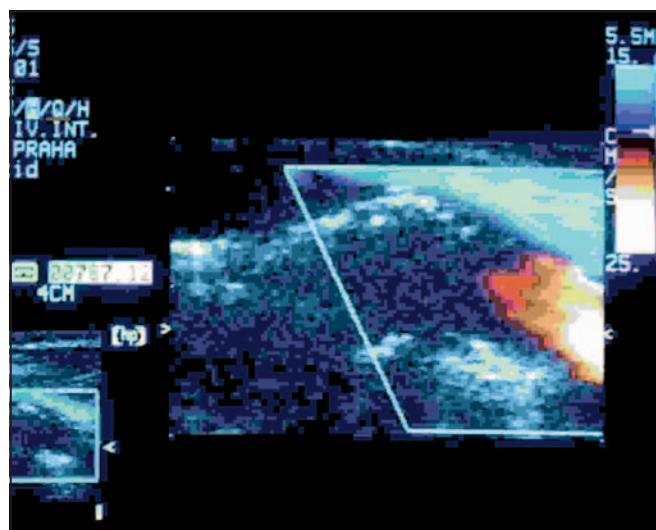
Duplex sonography of the origin of left internal carotid artery. Previously occurring thrombus is missing, there is a low plaque on the anterior wall of the bulb of the common carotid artery
